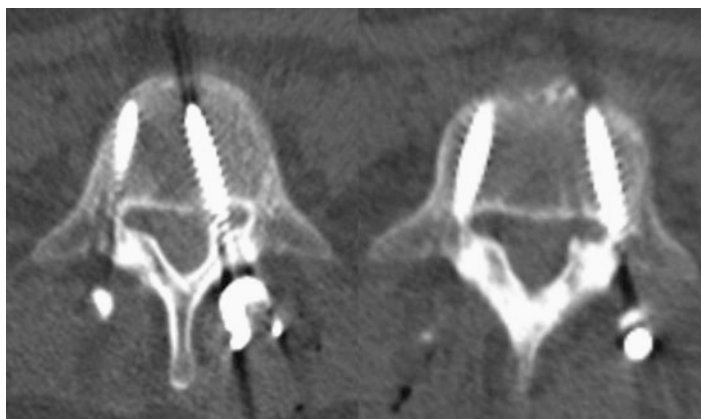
Intra 3D-CT (*left*) three-dimensional CT (*left*) of a patient harbouring a sacral neurinoma. Tumour removal was done including lumbar-pelvic fixation (*right*). Note the different inclination and orientation of the screws within the spine and the pelvis
